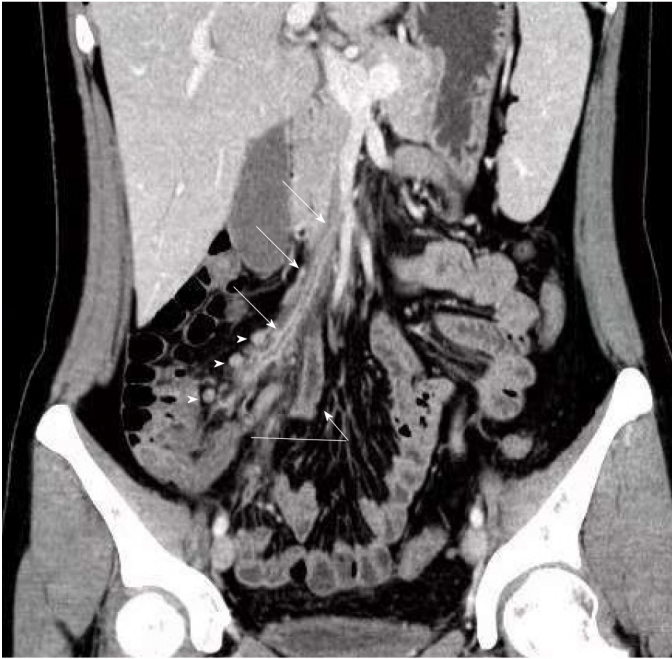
Contrast-enhanced computed tomography coronal reformatted image in the portal vein phase showed a filling defect consistent with a clot in the ileocolic vein (arrow) associated with surrounding inflammation of fat up to the superior mesenteric vein. Substantial appendiceal enlargement with inflammation indicative of acute appendicitis was observed (curve arrow). Moreover, enlarged lymph nodes within the mesentery was seen (arrowhead).
